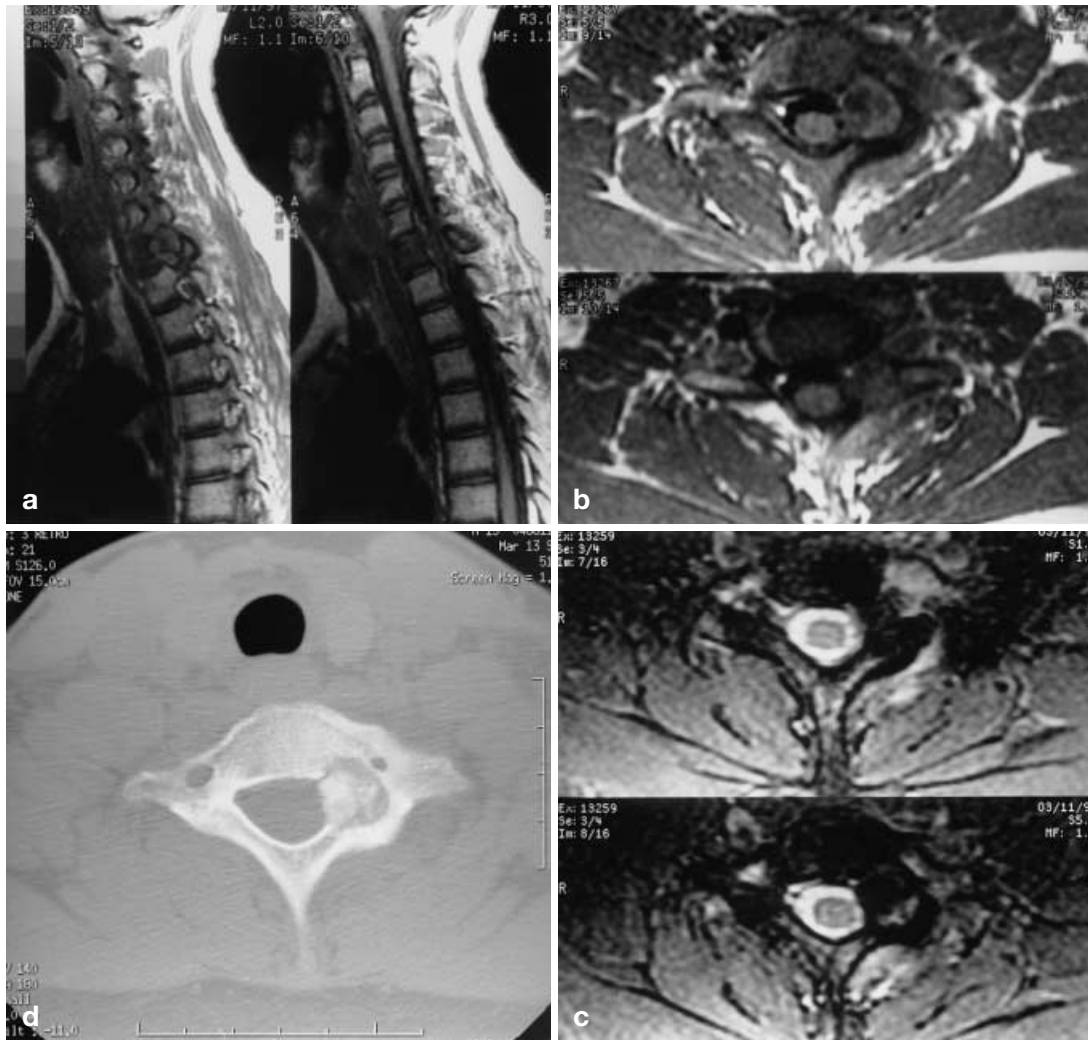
Sagittal (a) (TR:650, TE:15), and axial (b) (TR:600, TE:15) T1-weighted images of case 2 (15-year-old boy) male demonstrate replacement of the normal vertebral marrow with decreased T1 signal. The axial gradient echo image (c) (TR:550, TE:15) demonstrates increased marrow signal due to edema, as well as edema within the paraspinal soft tissues. The CT examination (d) demonstrates the characteristic nidus and perinidal lucency at the level of the C7 pedicle
